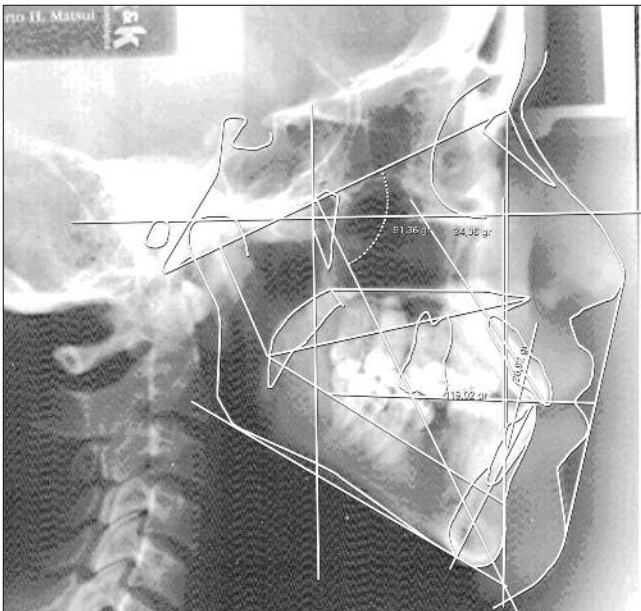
Ricketts' cephalometric analysis using a conventionally obtained radiography
